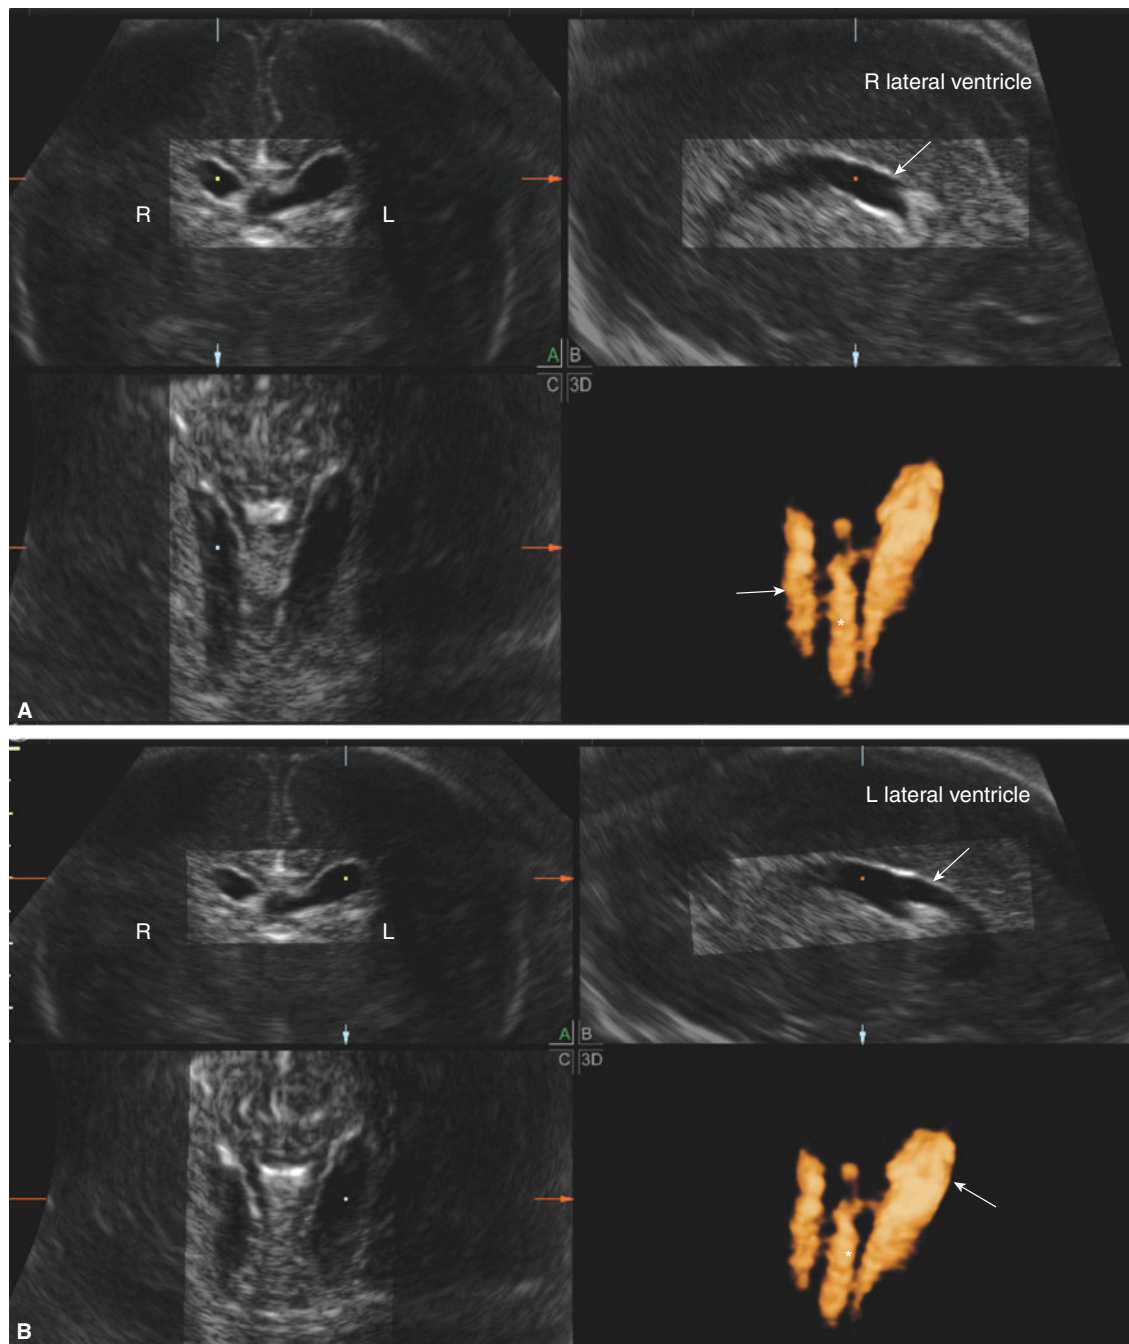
Multiplanar display of an ultrasound volume of a normal fetal brain at 21 weeks. The three orthogonal planes, coronal, sagittal, and axial planes, of the right and left lateral ventricles are presented in images a and b, respectively. Inversion mode demonstrates the shape of both lateral ventricles (arrows) and the cavum septi pellucidi (asterisk). Note the asymmetry of both ventricles depicted in both imaging modalities.
